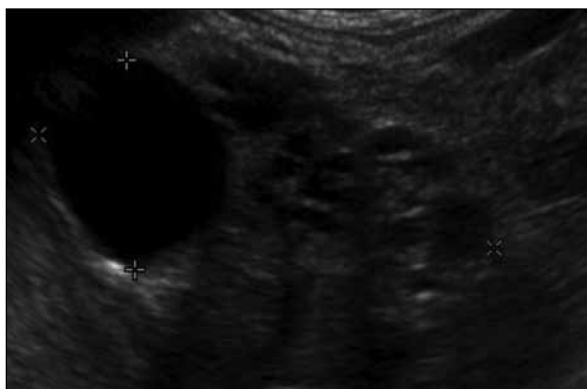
Ultrasonography of the left kidney showing multiple cysts of varying sizes replacing the left kidney, with no communication between the cysts. The largest cyst is peripherally located
